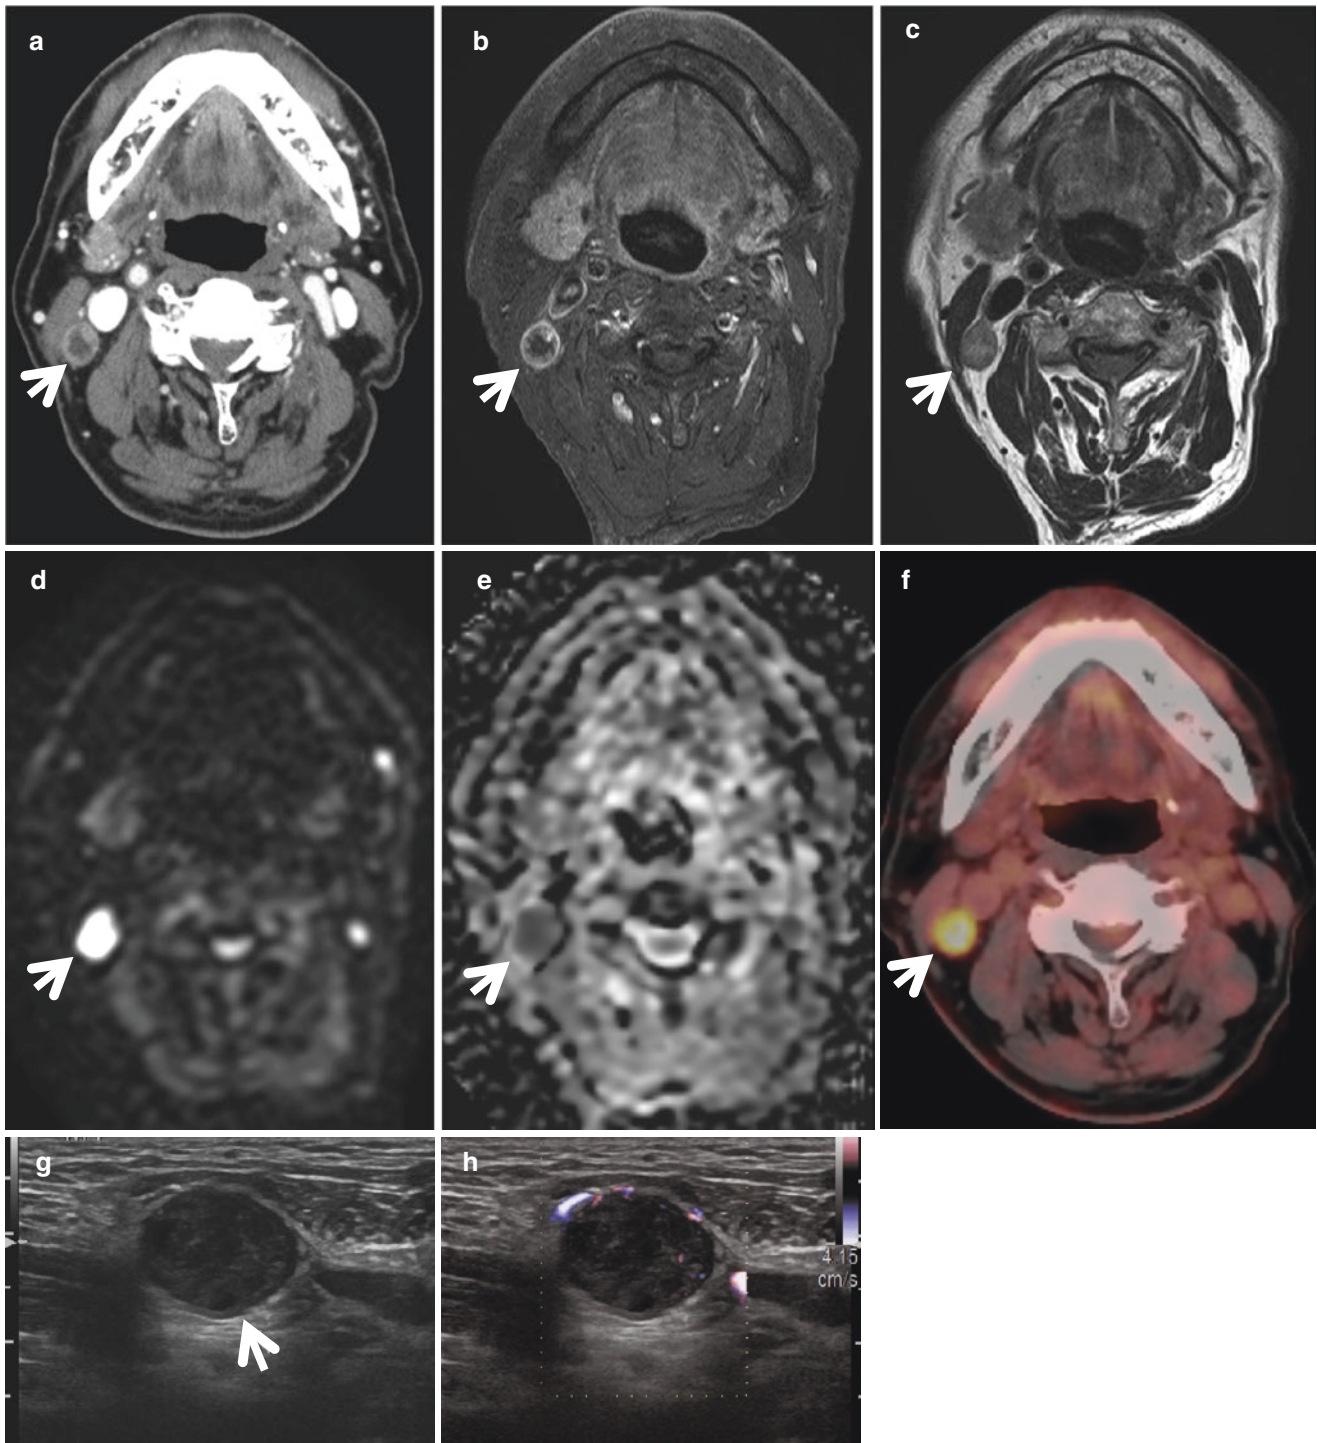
Metastatic right level II node (*arrow*) from hypopharyngeal cancer exceeds 11 mm in minimum diameter with focal inhomogeneity on both enhanced CT (a) and T1WI (b), intermediate intensity on T2WI
